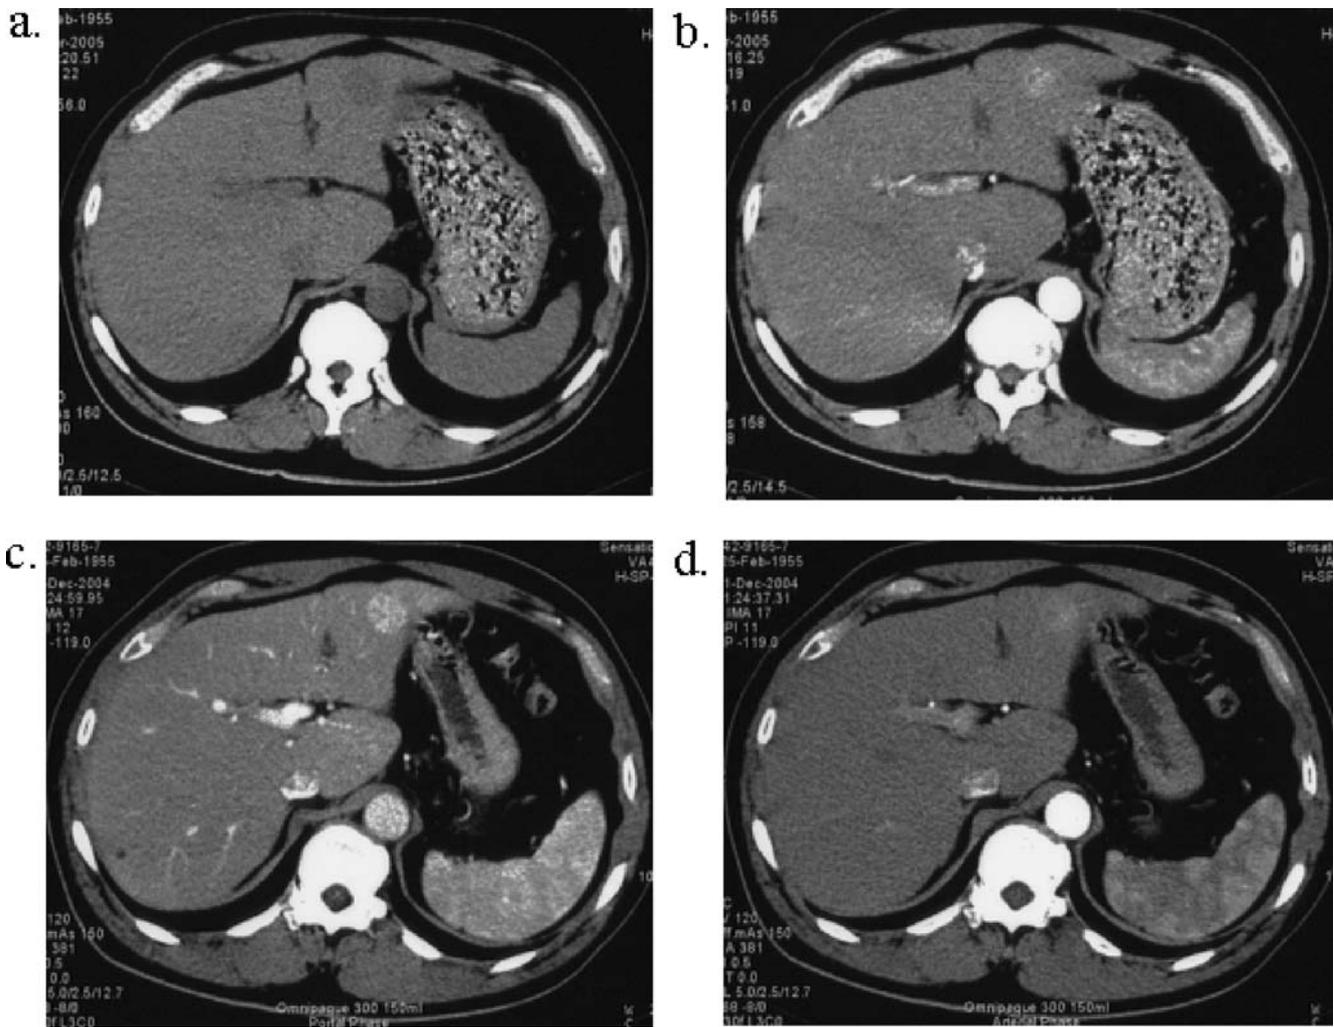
CT. a Nonenhanced CT demonstrated a well-defined, low-density mass in segment III without bile duct dilatation. b Enhanced CT of the arterial phase shows a slightly enhanced mass. c The mass
